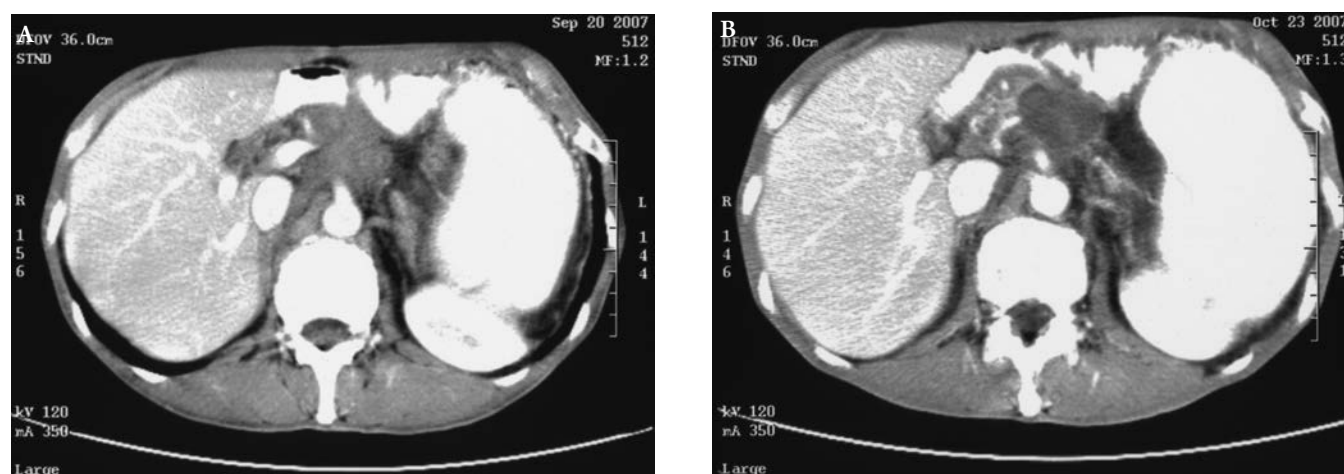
Contrast enhanced-CT scan of a 52-year-old male demonstrating a tumor in the body of the pancreas (A) prior to high intensity focused ultrasound therapy; (B) with evidence of ablation and necrosis following high intensity focused ultrasound therapy. Reproduced with permission from Xiong et al. 2009 (13).
